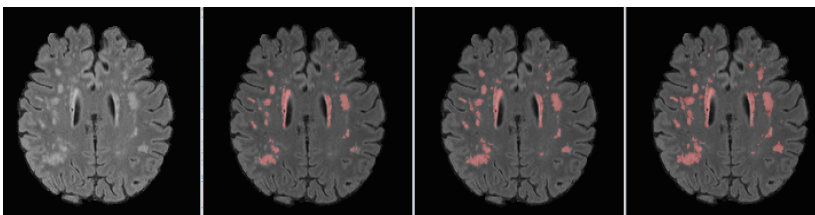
FLAIR, lesion segmentation (first iteration), lesion segmentation (third iteration), and manual delineation
